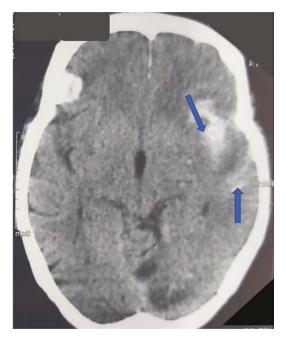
CT scan of head showing hyperdensity in the left frontal and temporal lobe area corresponding to the sulci of the sylvian fissure. The hyperdensity follows the pattern in the subarachnoid space of the corresponding sulcus. <u>Impression</u>: Posttraumatic subarachnoid hemorrhage (SAH)
